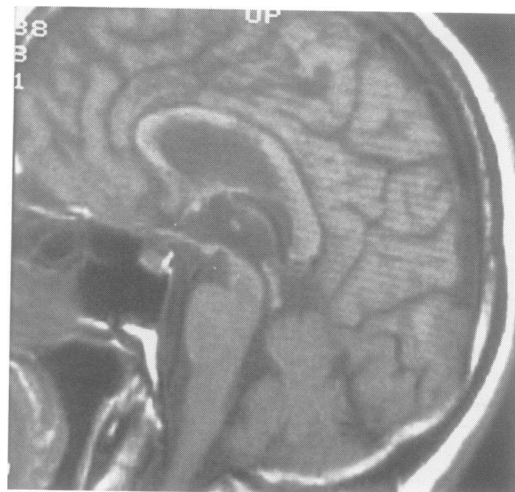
(patient 3) Large infarct in the middle of the corpus callosum, on sagittal T1 weighted MRI.
